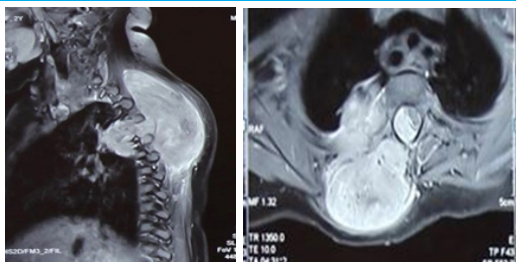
Contrast MRI of dorsal spine which shows heterogeneous enhancement.
